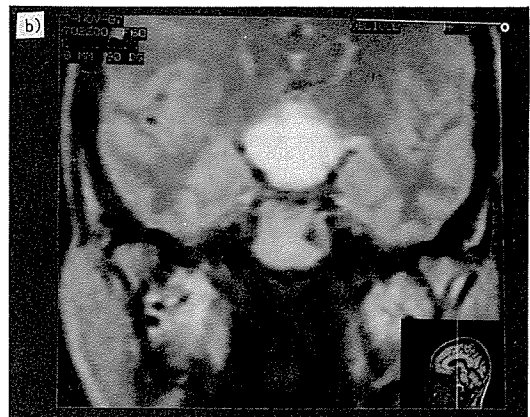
Digit learning pattern on a 60-year old female with craniopharyngioma. a) Inability to learn a 7-digit-number without perseveration. b) MRI demonstrating craniopharyngioma destroying the Papez medial limbic circuit.
